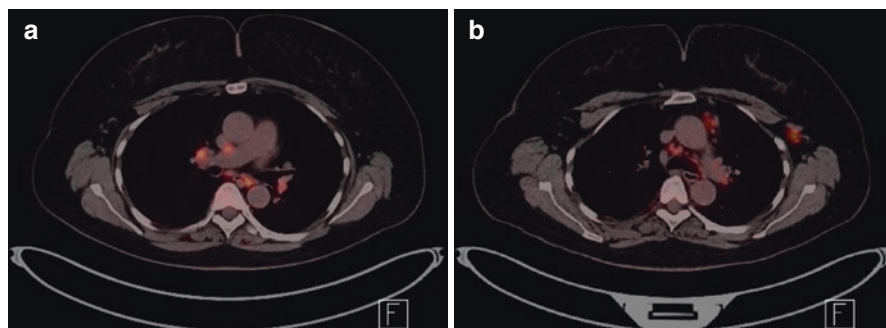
CT PET scan showing uptake of FDG tracer in the cervical lymph nodes on both sides, the left axilla and the upper mediastinum. There were also nodes within the abdomen
